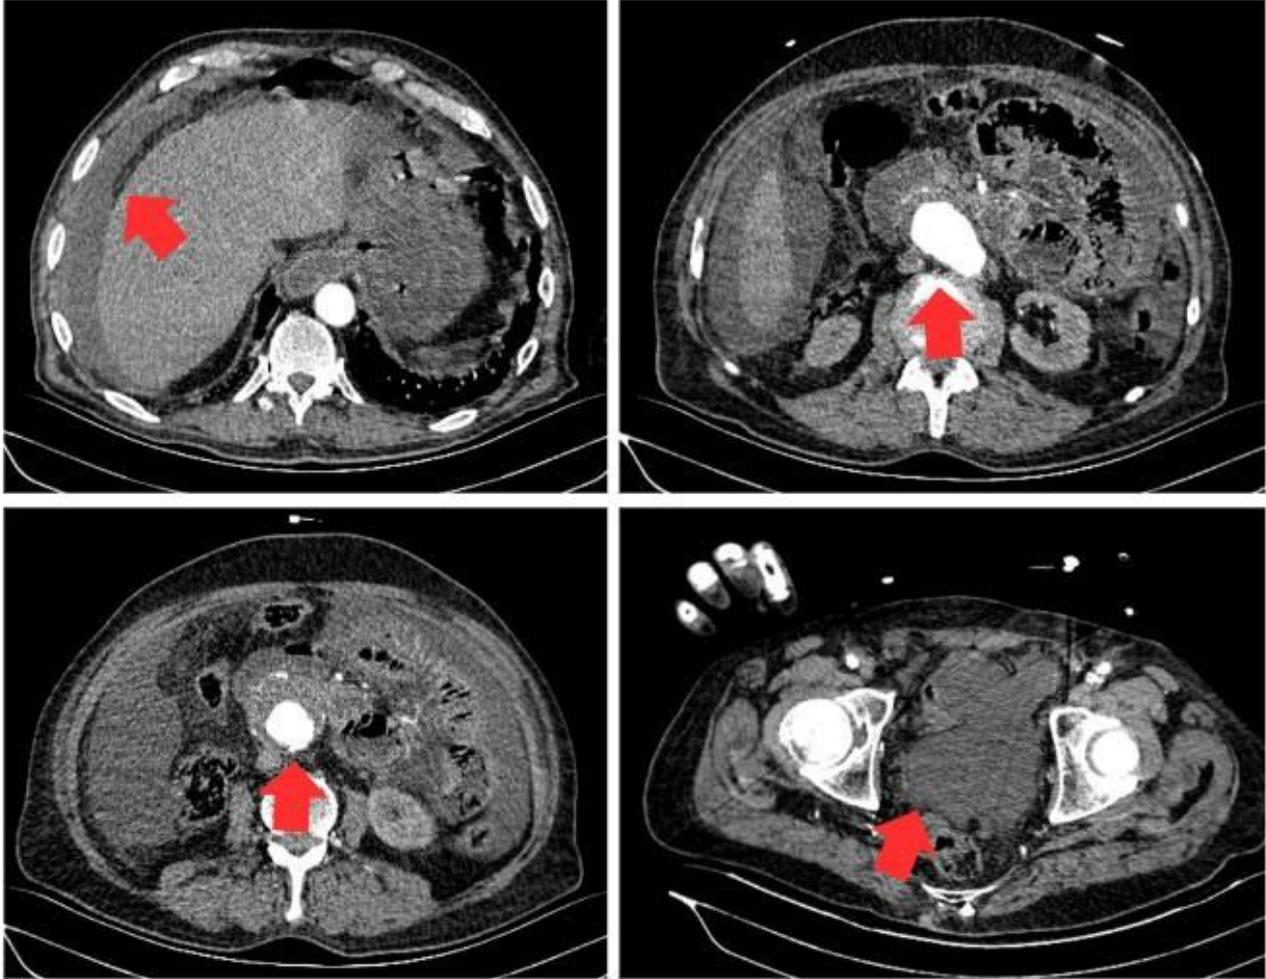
Contrast-enhanced CT angiography demonstrates widespread free fluid around the liver and in the pelvic region, as well as aneurysmal dilation and intramural thrombus formation within the abdominal aorta (arrows).
